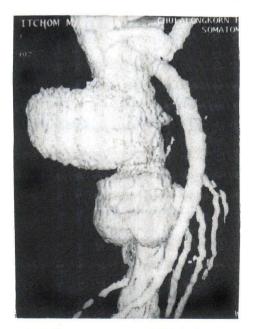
3-D reformation of CTA show a large bi-lobed saccular aneurysm.
